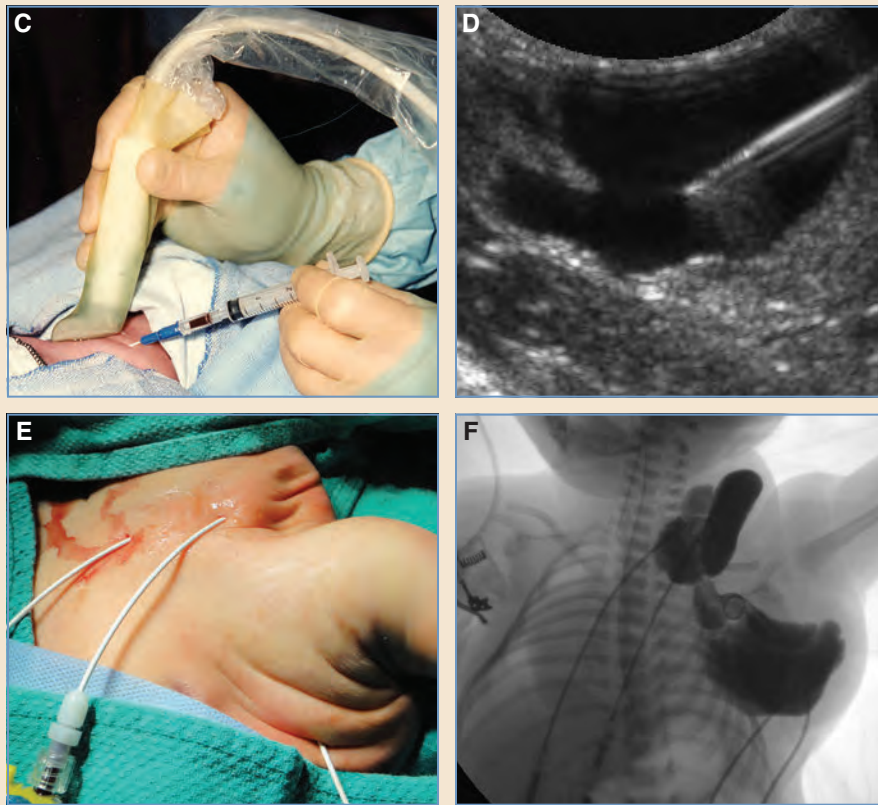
cont'd C and D, Ultrasonographic guidance used to puncture cysts. E, Larger cysts drained and cysts aspirated before sclerosant injection. F, Contrast injected through drains to outline cysts before sclerosant injection. We no longer inject contrast for such routine cases.
